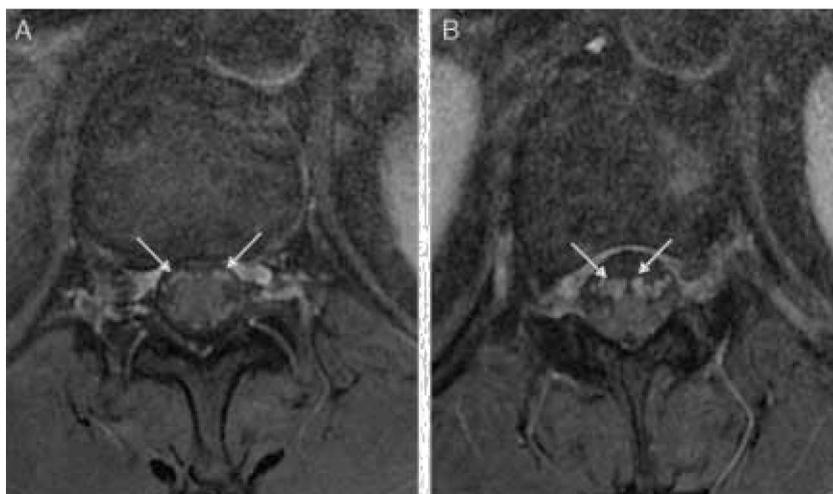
Fat-suppressed T1-weighted axial MRI showing enhancement of the anterior nerve roots in D12 and L1 and in the conus medullaris.
